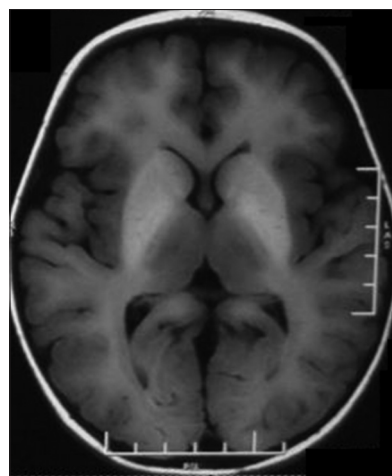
MRI brain T1-weighted axial scan showing hyperintensities in bilateral globuspallidi suggestive of mineral deposition
